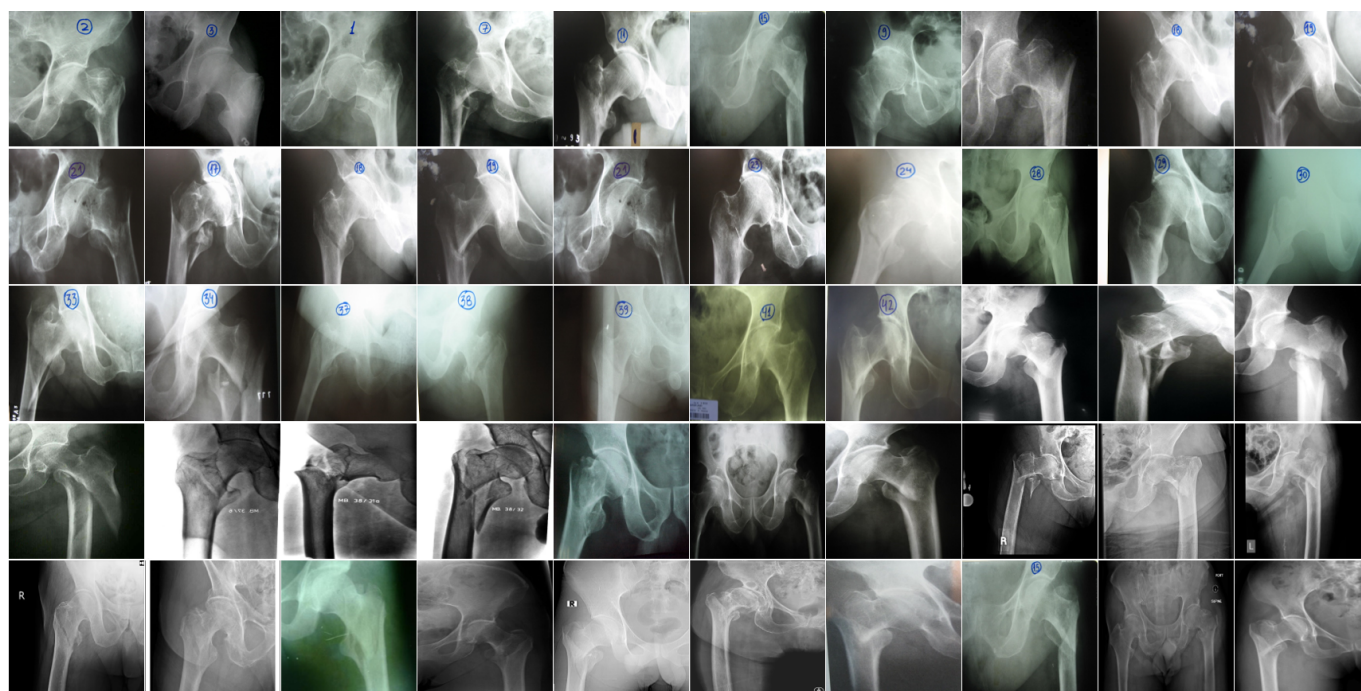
Image of the 50 radiographs used for the assessment.
